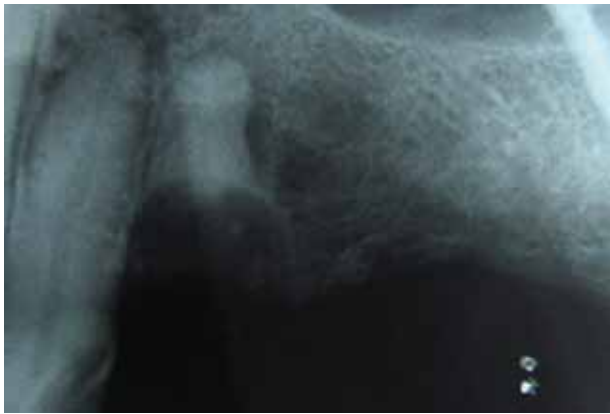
IOPA Radiograph of 23, 24 region, showing ill-defined bone loss and retained root stump of 23
